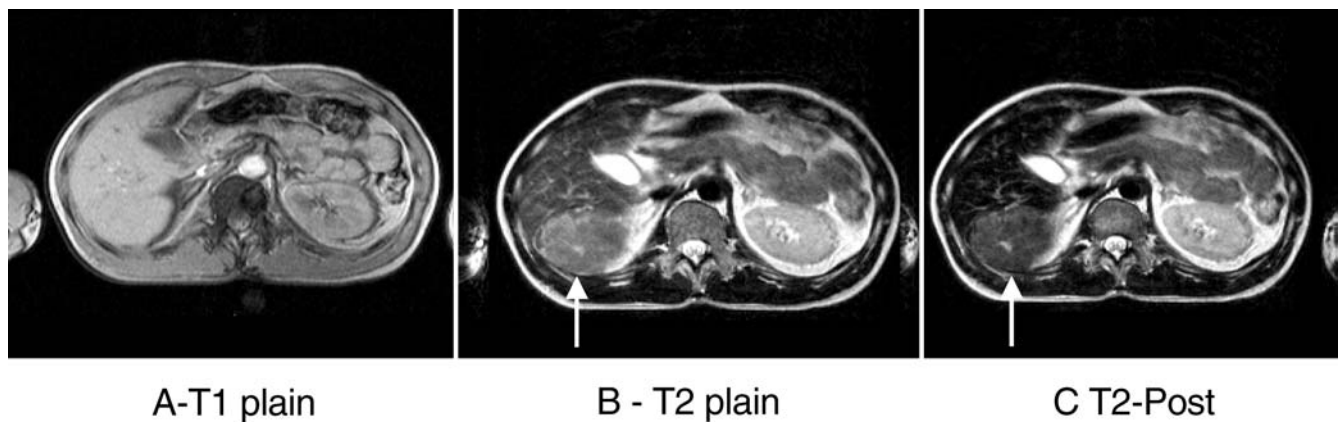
Focal nodular hyperplasia (FNH) accumulation-phase images for characterization. Plain a T1-weighted, b T2-weighted TSE, and c ferucarbotran-enhanced T2-weighted TSE images of a patient with FNH show a signal decrease within the tumor post contrast due to reticuloendothelial system activity within the lesion. The central scar remains hyperintense (images courtesy of F. Oeckers)
